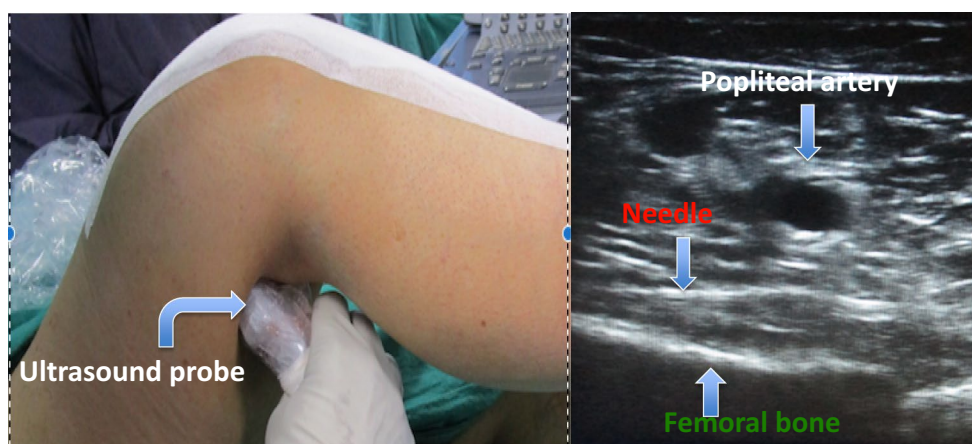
a The ultrasound probe is placed in the popliteal fossa on the lateral side and the needle introduced posteromedially with the patient placed in supine position. b Popliteal artery, femoral bone
